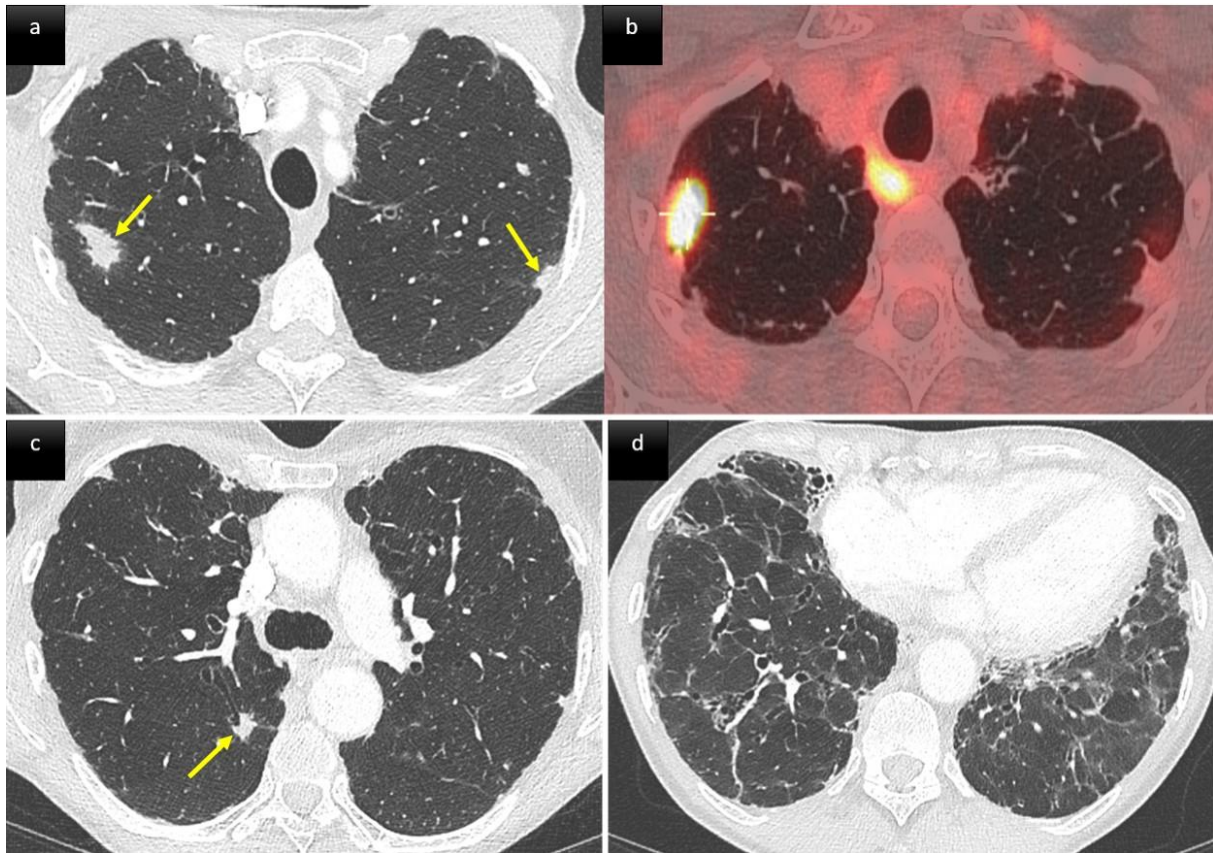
A 71-year-old woman with CVID and GLILD. Unenhanced CT scan (a, c, d) and PET CT scan (b) images. Patchy ground glass and evidence of parenchymal distortion and fibrosis in the lower lobes (d) are regarded as the consequence of longstanding GLILD and repeated infections. The subpleural and broncho centric nodular opacities in the upper lobes (arrows), were slowly progressive over time. The larger nodule showed intense FDG-uptake (b) that led to a CT guided biopsy of the nodule to exclude lymphoma. The histo-pathological result confirmed a new GLILD localization
